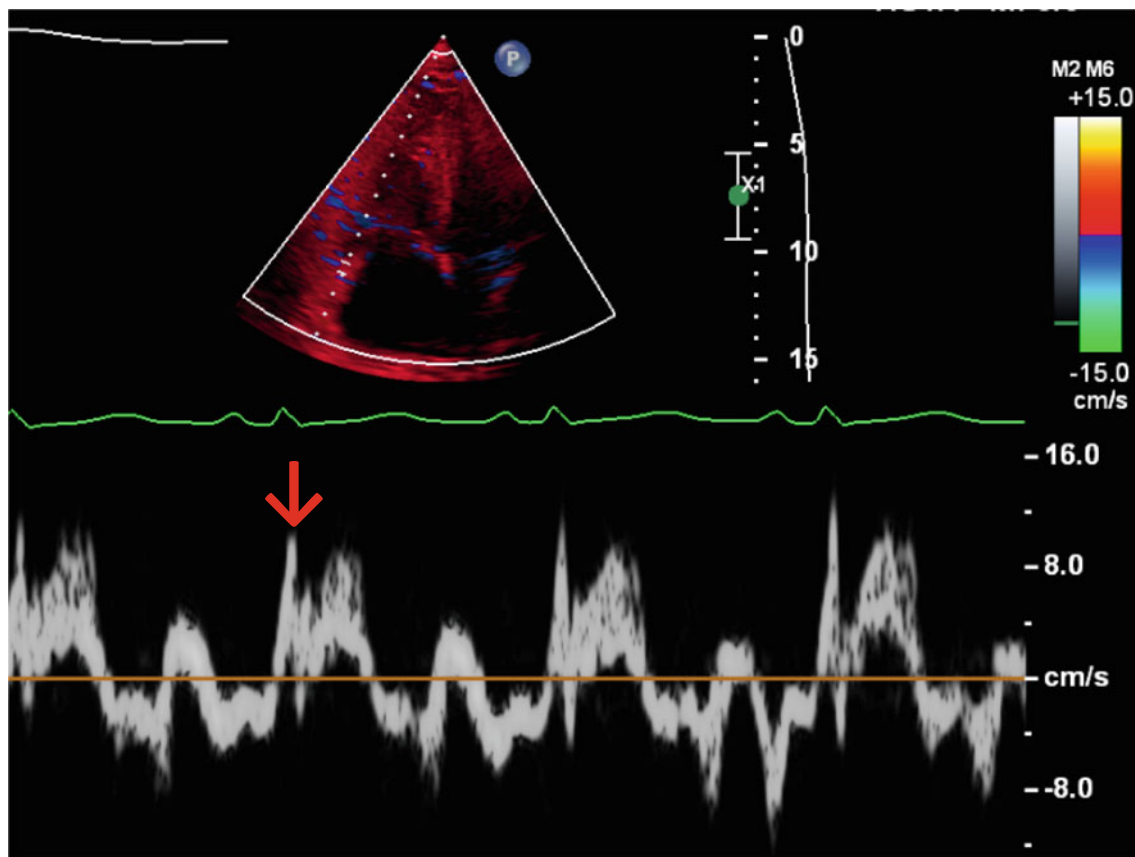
Transthoracic echocardiogram: reduced RV systolic function by myocardial systolic excursion velocity (S') (arrow)
